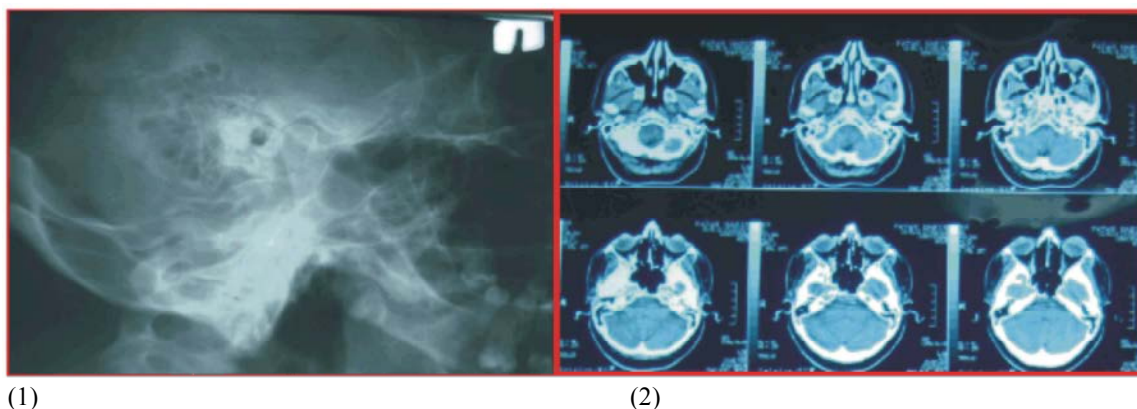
The graphy of temporal and paranasal sinus CT (was normal)
